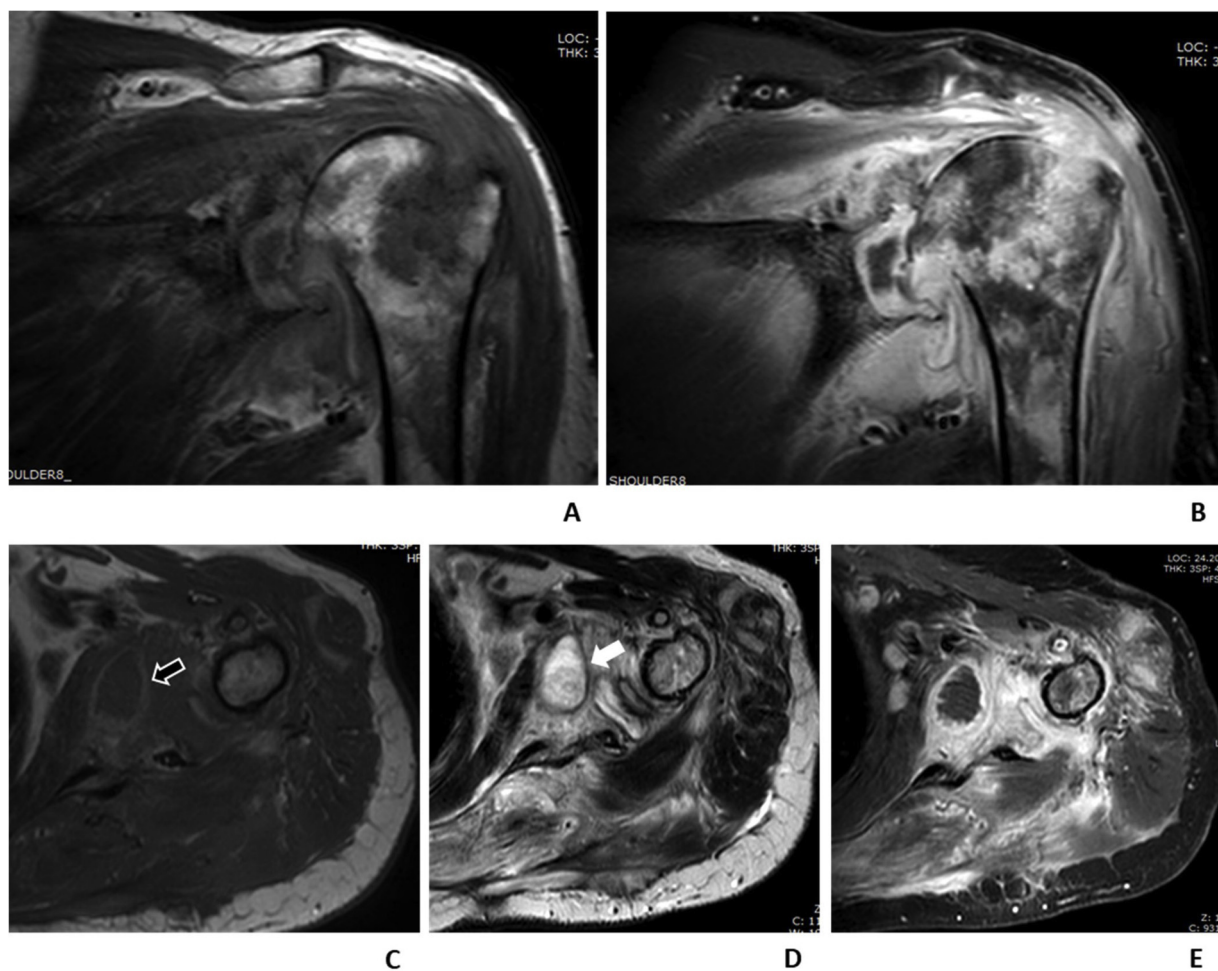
53-year-old man with secondary tuberculous pyomyositis. Coronal T1-weighted and contrast-enhanced T1-weighted fast spin echo (FSE) images (A) (B) show septic arthritis and osteomyelitis at the shoulder. Axial T1-weighted FSE image (C) shows hyperintense abscess wall (black arrow). Axial T2-weighted FSE image (D) shows hypointense at the abscess wall (white arrow). Axial contrast-enhanced T1-weighted FSE image (E), the abscess shows irregular thin wall without internal septal enhancement.
